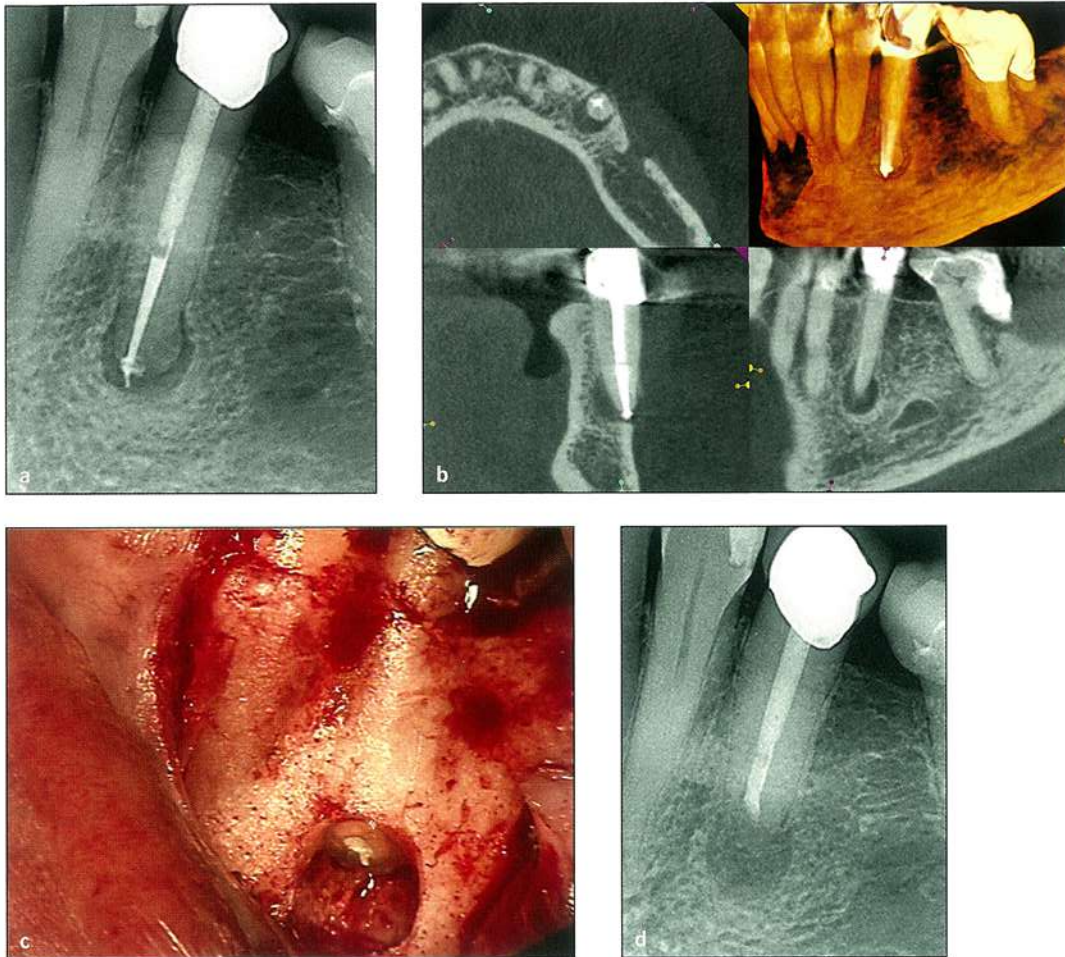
(a) Preoperative radiograph. (b) CBCT scan. (c) Apical retrofilling. (d) Postoperative radiograph.
